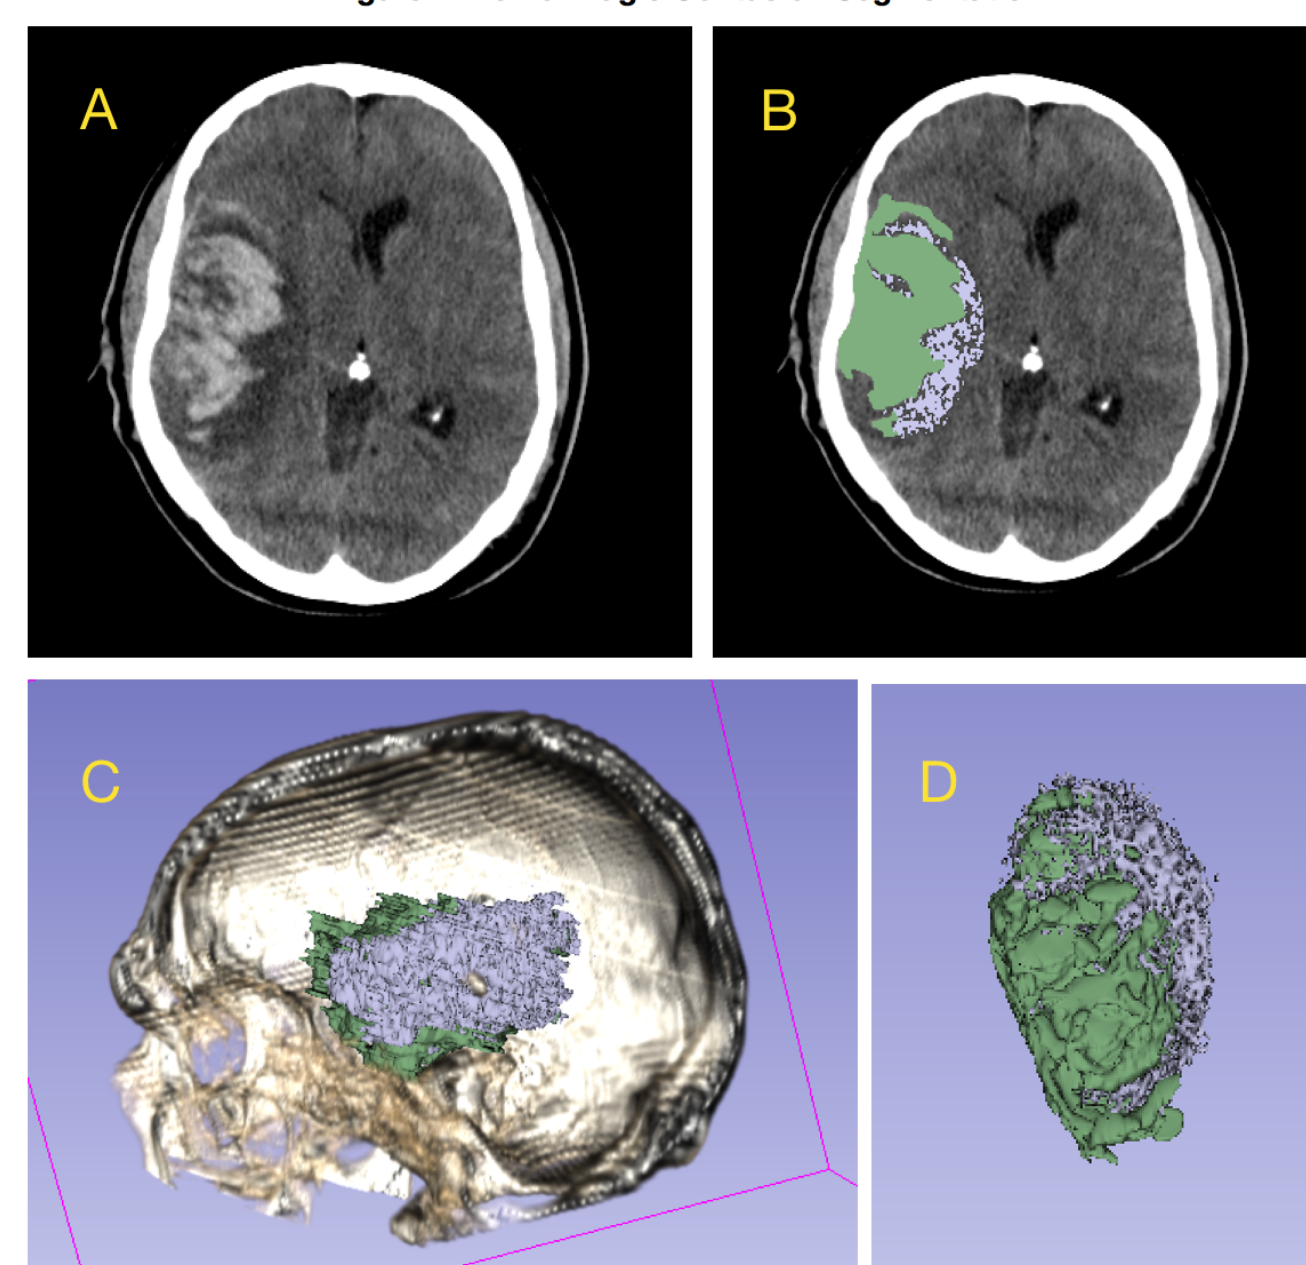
Axial section of CT scan showing hemorrhage and edema; Image B: Same axial section as A, segmented using PaintEffect on 3D Slicer; Image C: 3D model of the segmented hemorrhage and edema volumes localized in the skull; Image D: 3D model of segmented volumes in empty space
